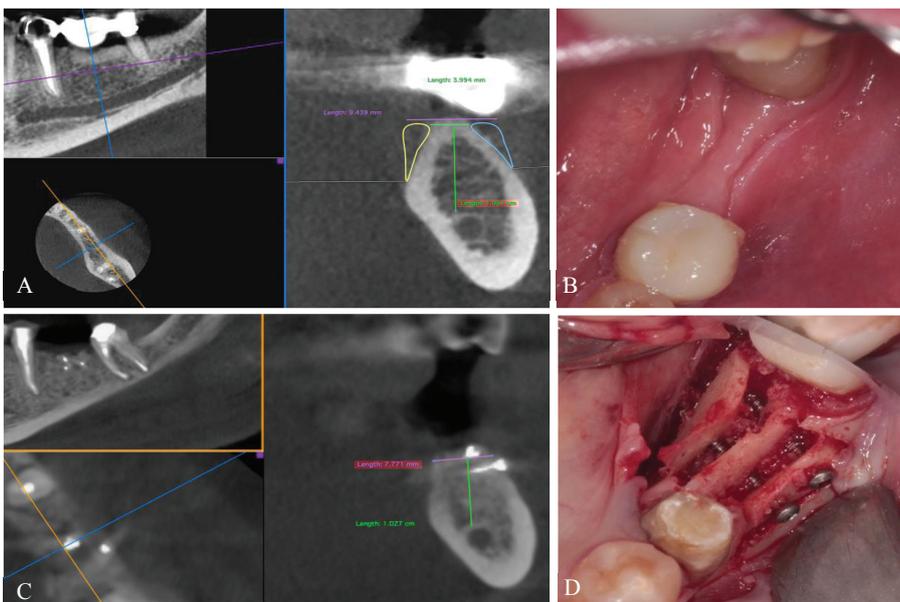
Stages of oral and vestibular RS: A – CBCT before operation, multi-planar reformation; B – Alveolar ridge before the operation; C – CBCT 4 month after reconstruction; D – Stage of operation. Splitting and displacement of the cortical block was performed lingually, fixation by microscrews to the vestibular plate
